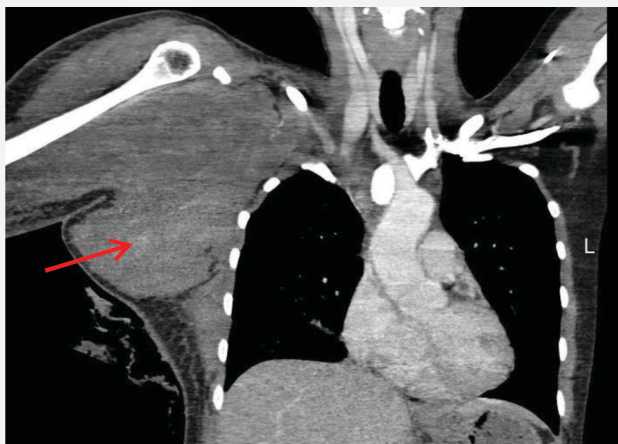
Chest CT scan with IV contrast showing an extrathoracic soft tissue sarcoma on the right posterolateral chest wall (red arrow).
